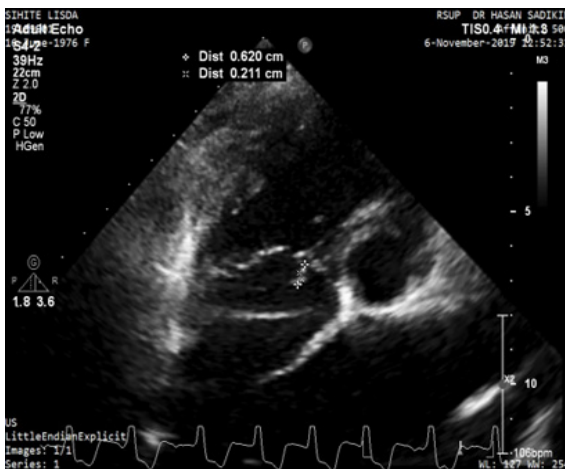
Echocardiography Showed Vegetation at Tricuspid Valve
